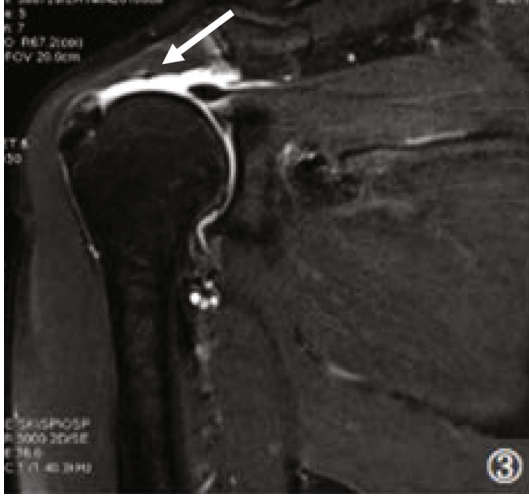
MRI grade 3 (the arrow pointed in the figure): the attachment end of the greater tuberosity of the humerus in the supraspinatus tendon indicated emptiness and was filled with liquid signal shadow. It was found that the continuity of the tendon was interrupted and the broken ends were retracted. Effusion in the deltoid bursa below the acromion was found.
